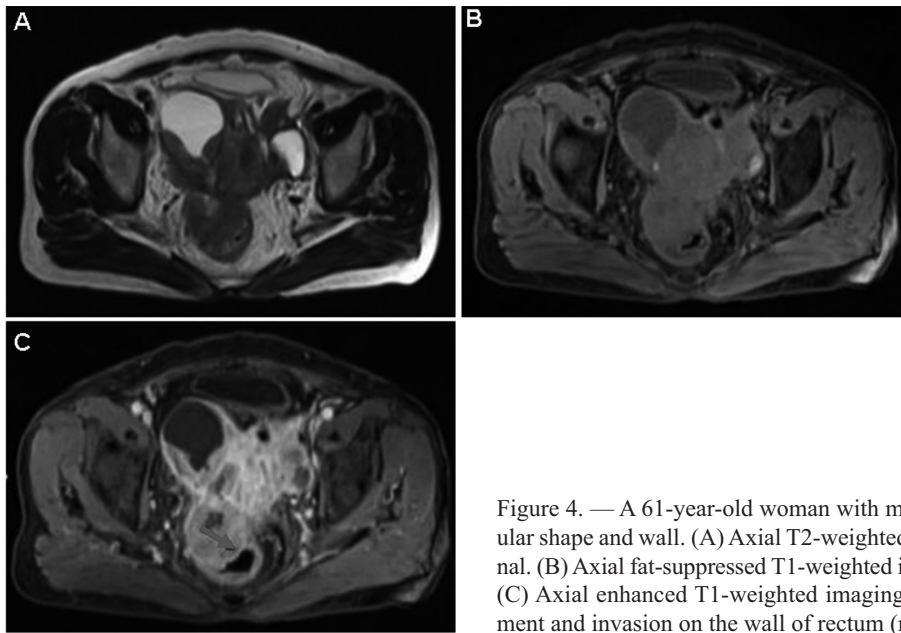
A 61-year-old woman with mucinous cystadenocarcinoma with irregular shape and wall. (A) Axial T2-weighted imaging shows high heterogeneous signal. (B) Axial fat-suppressed T1-weighted imaging shows low heterogeneous signal. (C) Axial enhanced T1-weighted imaging shows intense heterogeneous enhancement and invasion on the wall of rectum (red arrow) in the vein phase.
